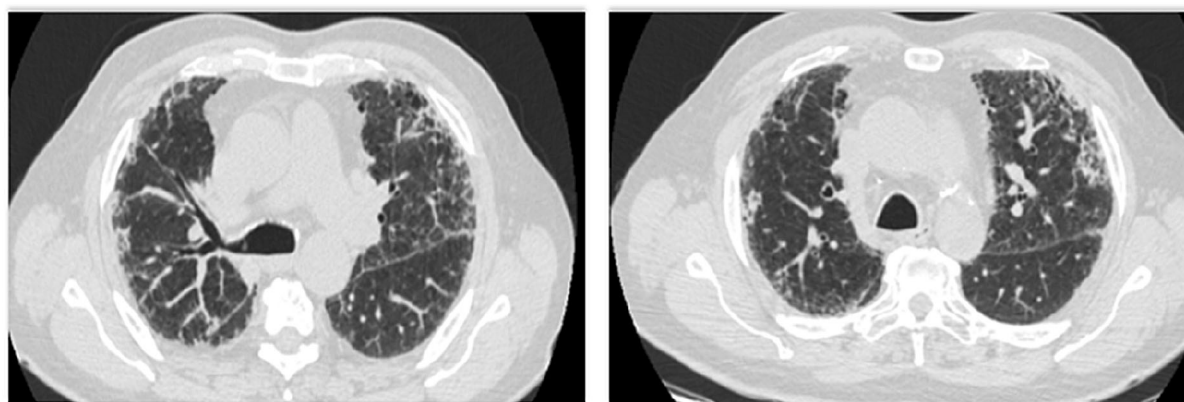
High-resolution chest CT performed in December 2016
